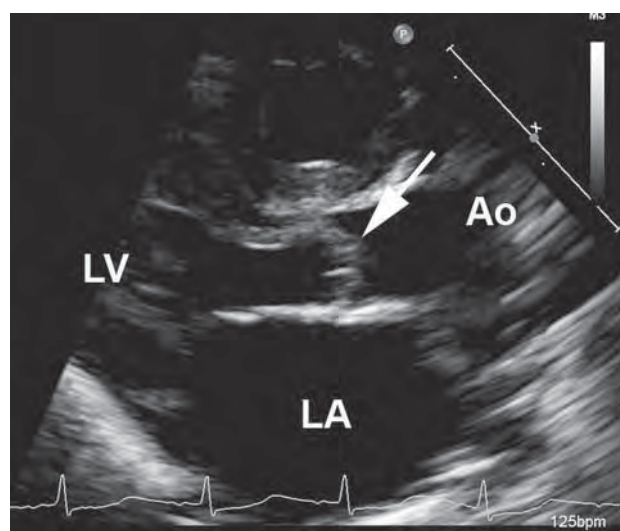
Parasternal long-axis echocardiography view showing the aortic valve cusps which are thickened (arrow), movie clip of this image is likely to show limited excursion of the aortic valve cusps. Ao, aorta; LA, left atrium; LV, left ventricle.
